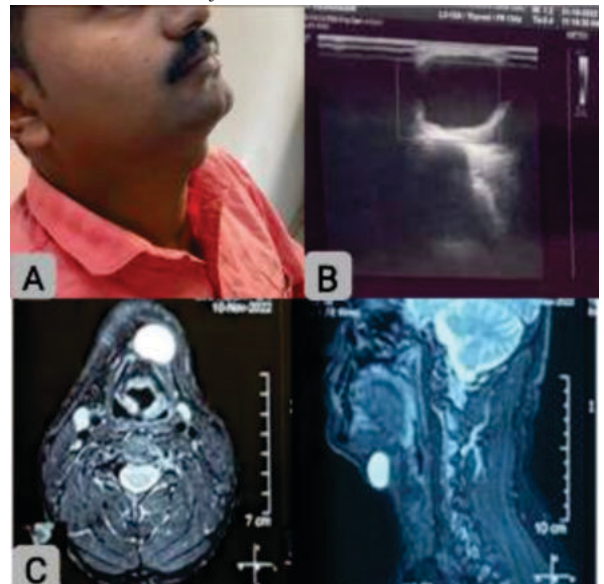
(a) Anterior Midline Neck Swelling (b) USG Showing Anechoic Cystic Lesion (c) MRI Showing Cystic Lesion Below Hyoid Bone in axial and sagittal section.
